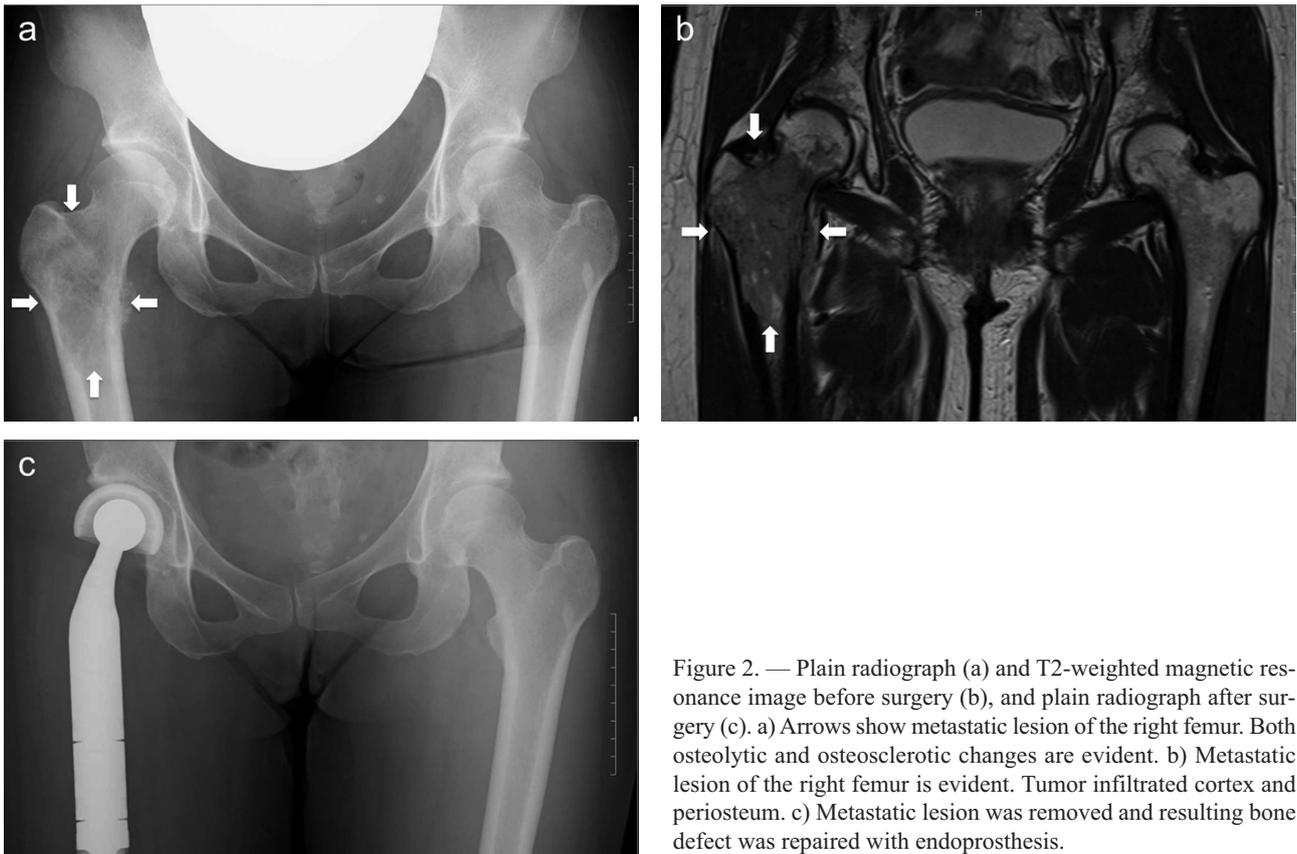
Plain radiograph (a) and T2-weighted magnetic resonance image before surgery (b), and plain radiograph after surgery (c). a) Arrows show metastatic lesion of the right femur. Both osteolytic and osteosclerotic changes are evident. b) Metastatic lesion of the right femur is evident. Tumor infiltrated cortex and periosteum. c) Metastatic lesion was removed and resulting bone defect was repaired with endoprosthesis.
